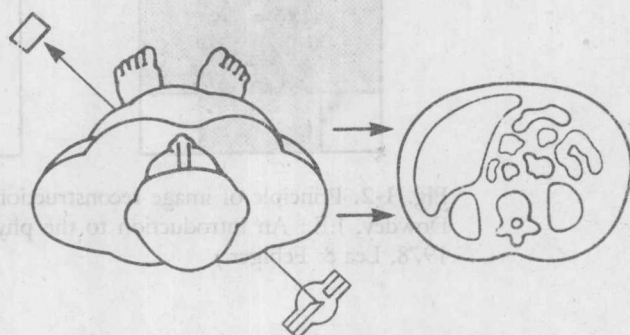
A CT image represents the anatomy of a transaxial slice of the body obtained from many transaxial x-ray attenuation measurements.
